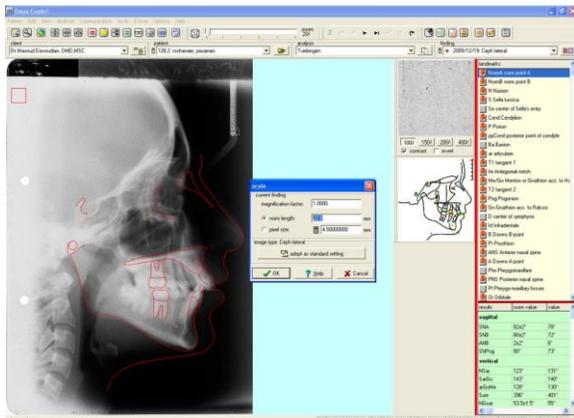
Calibrating of radiograph
